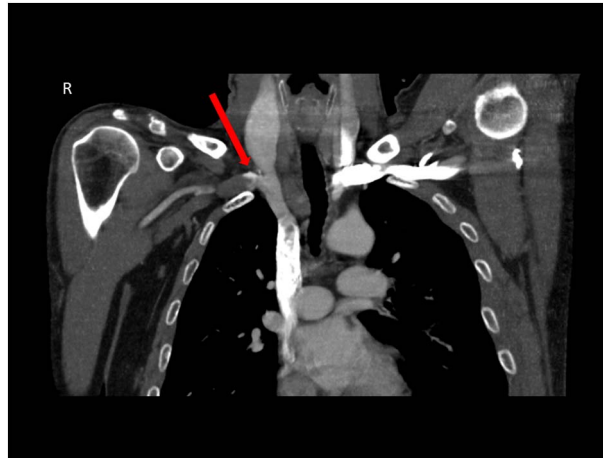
CTA showing distal innominate artery occlusion.
